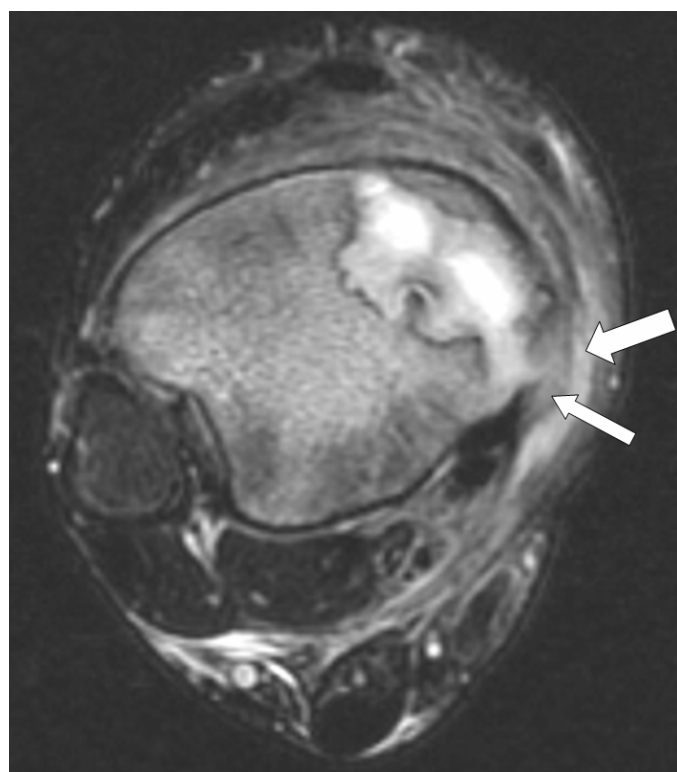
Figure 3A and B: Axial T2-weighted FSE MR images of right leg. In Figure 3B note extension of inflammatory process through cortex (narrow arrow) to involve adjacent soft tissues (wide arrow).
